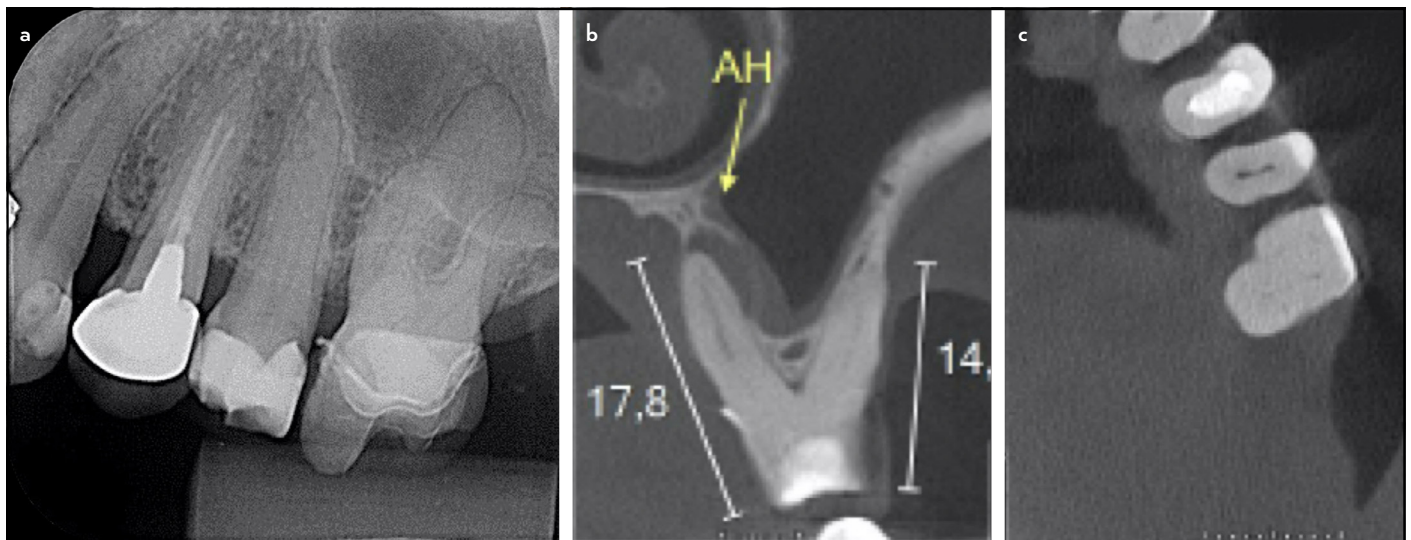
(a) Periapical radiograph showing PCO in the root canals, extensive restoration and slight widening of the periodontal ligament space in the palatal root of the upper left first molar; (b) Sagittal CBCT view showing hypodense area in the mesiobuccal and palatal roots; (c) Axial section confirming the presence of PCO.
